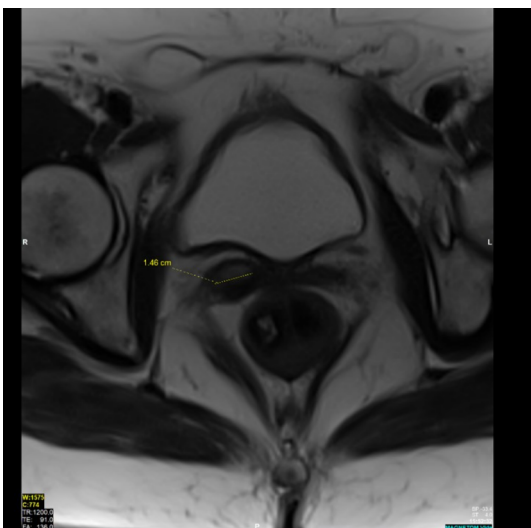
A cross-sectional MRI of patient's pelvis showing a 1.46cm T2 hyperintense, T1 isointense mass on the right lateral aspect of the vaginal vault stump. This demonstrates restricted diffusion.
